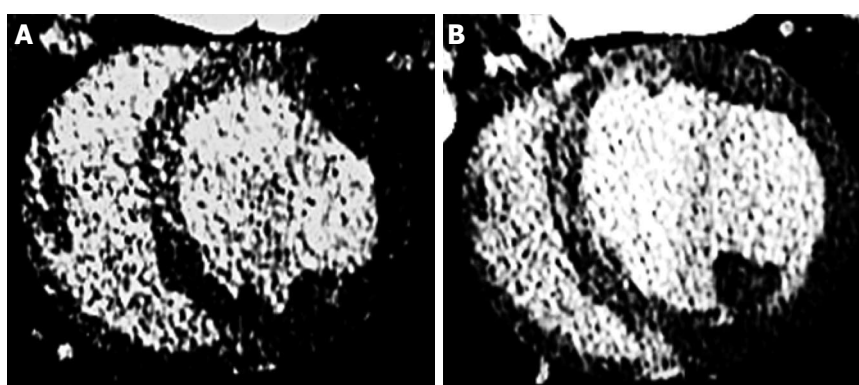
Delayed contrast enhanced multi-detector computed tomography 3 d after microembolization using 16 mm³ (A) and 32 mm³ (B) microemboli.
